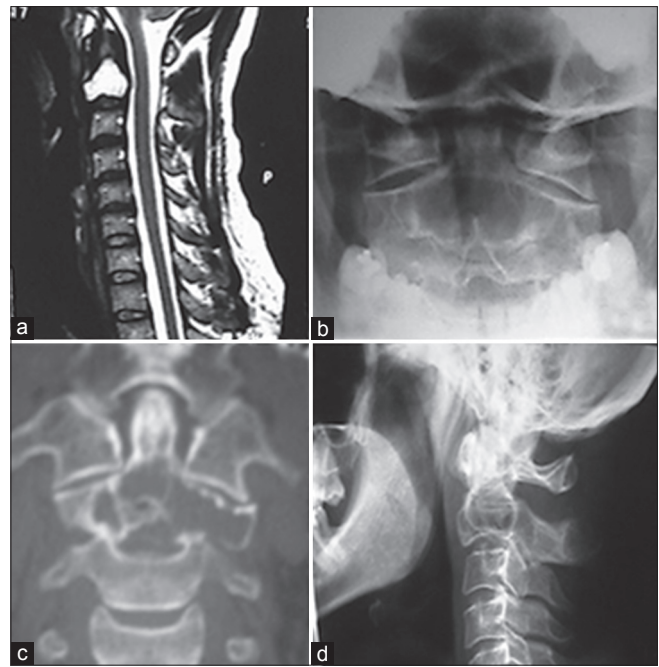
(a) T1 signal intensity sagittal magnetic resonance imaging showing a hyperintense lesion in C2, (b and d) plain film showing no instability, (c) computed tomography showing lytic lesion with sclerotic margins
